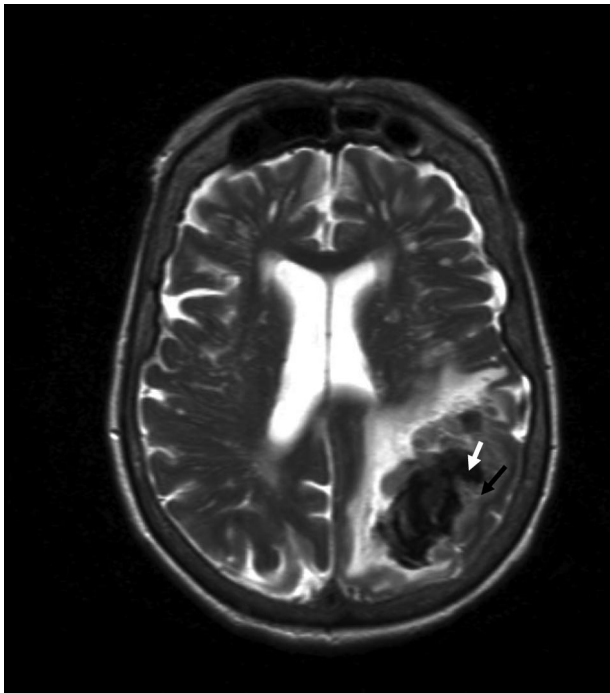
T2-weighted magnetic resonance image showing mixed hypointensity (white arrow) and isointensity (black arrow) signals representing an acute hemorrhage at left parietal lobe.
